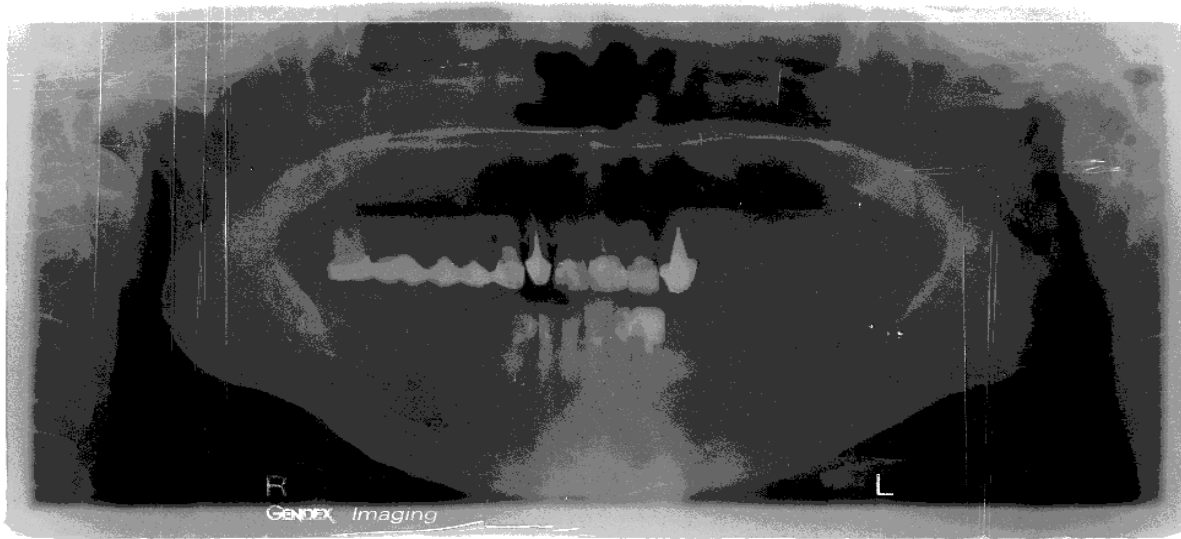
X-ray panoramic image.
